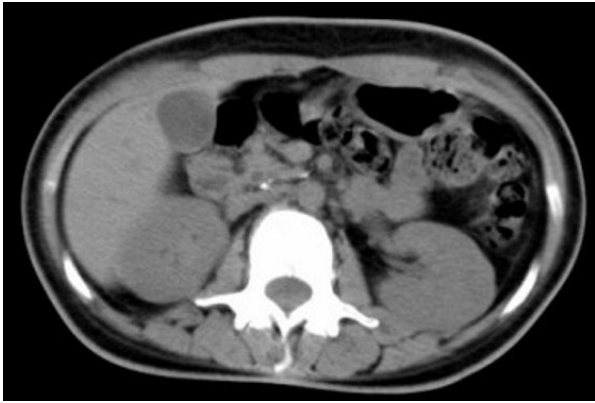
CT scan of the abdomen showing a slightly atrophic head of the pancreas with specks of calcification, and non-visualization of the body and the tail of pancreas.
